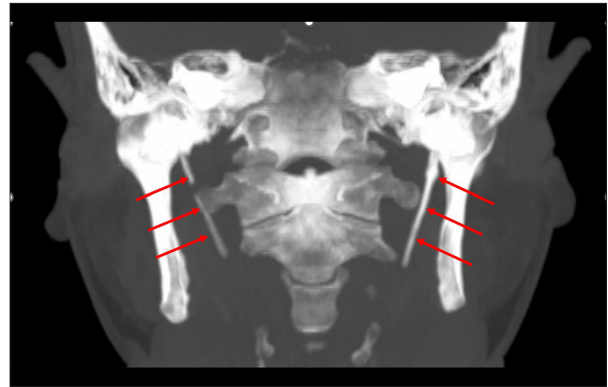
This is a non-contrasted CT of the neck, which demonstrated bilateral styloid process elongation (red arrows). It is the coronal maximum intensity projection image of the CT scan on bone setting showing bilateral styloid process elongation.
